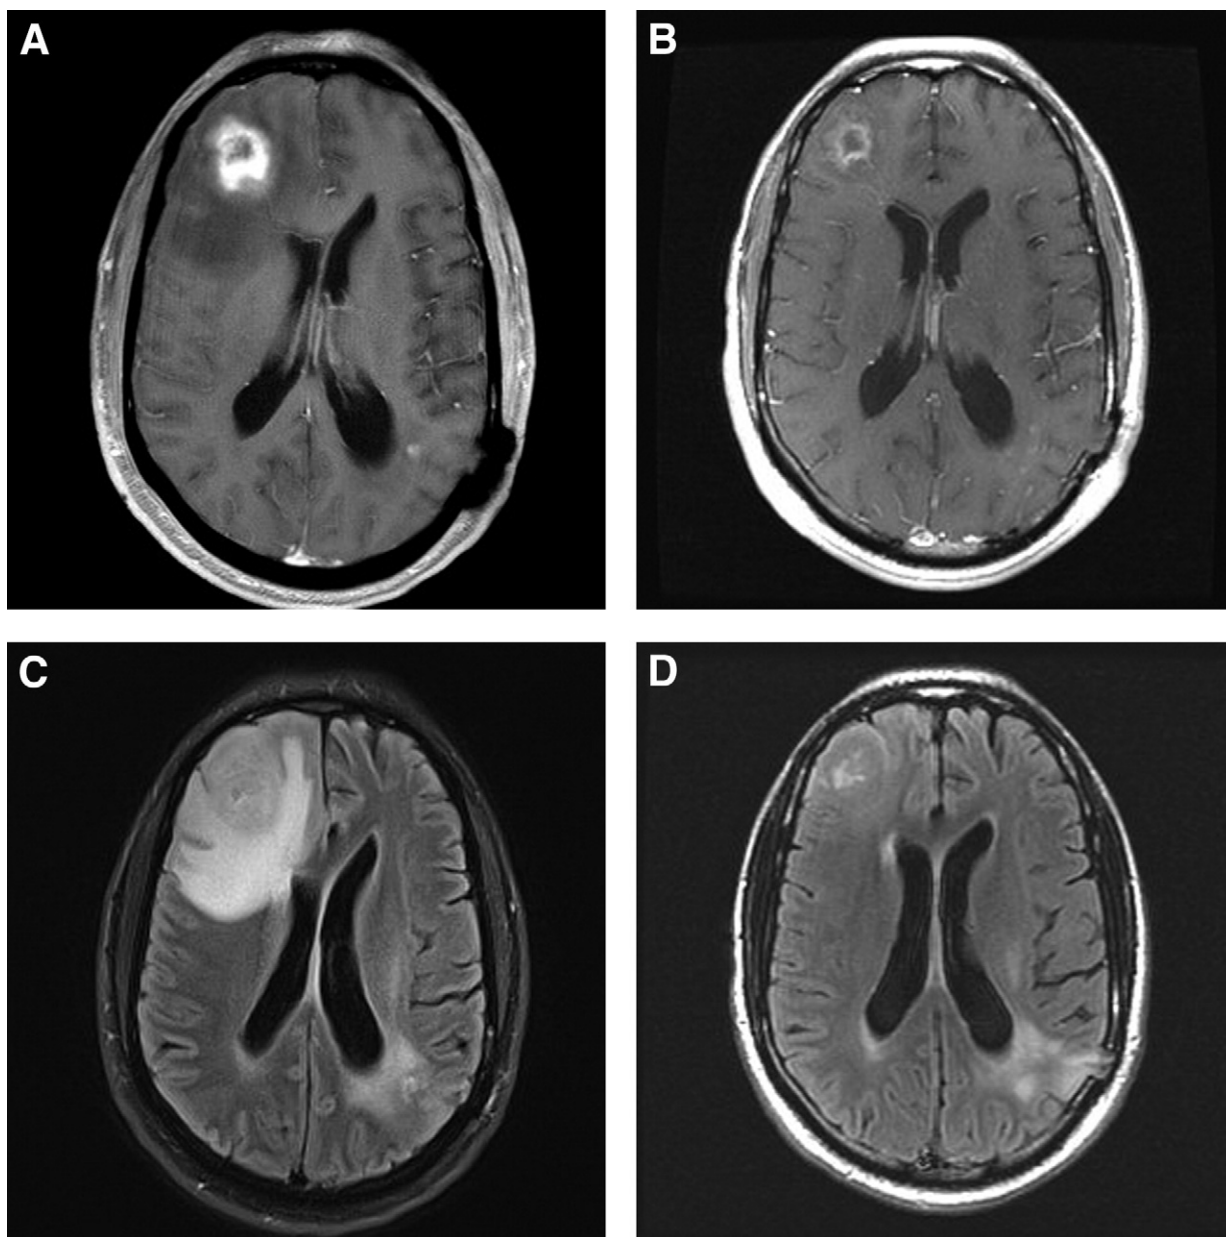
Axial T₁-contrast enhanced MRI of a 40-year-old man with a multifocal recurrent glioblastoma (A) before and (B) 8 weeks after treatment with XL-184 (VEGFR and Met inhibitor) showing a significant decrease in enhancement. In the same patient, axial FLAIR MRI (C) before and (D) after treatment shows the reduction in edema that correlated with symptomatic improvement.
